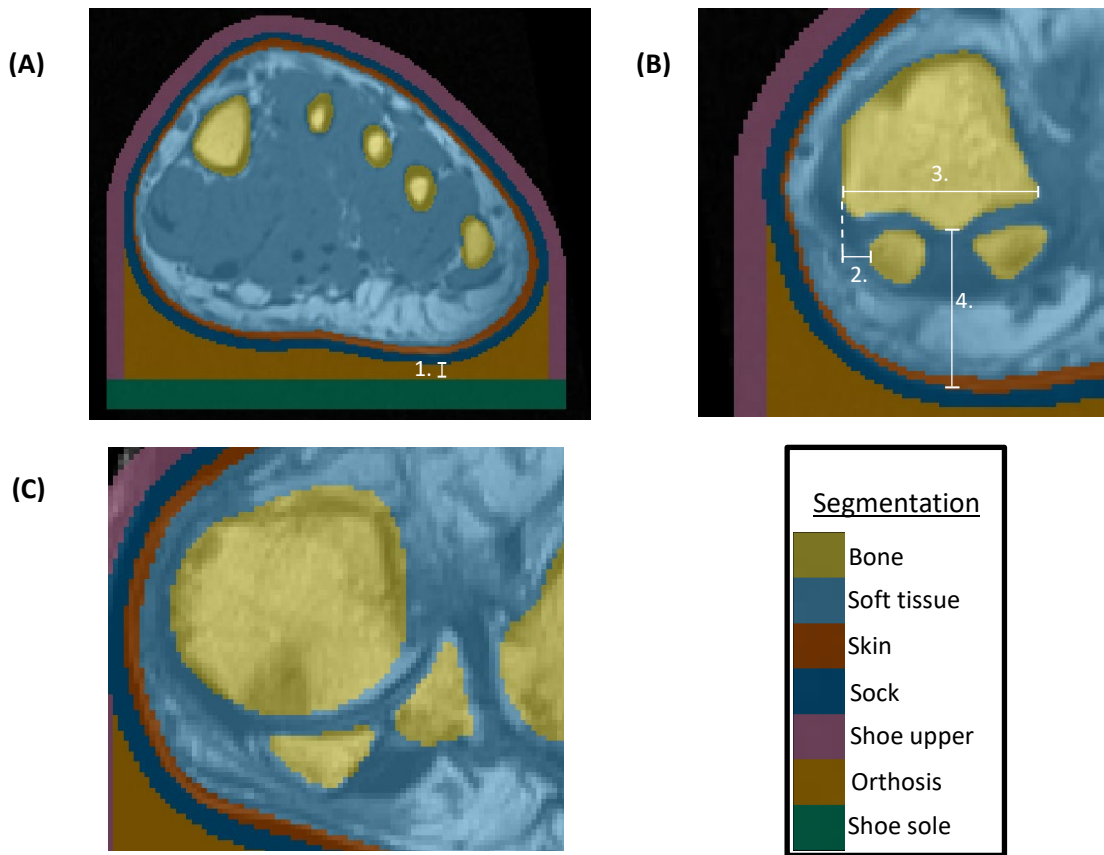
A) Segmentation of bones, skin, soft tissue from RA3 MRI, with addition of sock, shoe upper, orthosis, shoe sole, indicating minimum orthosis depth (1.); B) Morphological measurements for RA3 showing sesamoids in a normal position, with 2. Lateral distance from MH1 edge to sesamoid, 3. MH1 width, 4. Tissue depth under MH1 C) RA1 MRI showing example of sesamoids in a displaced position
